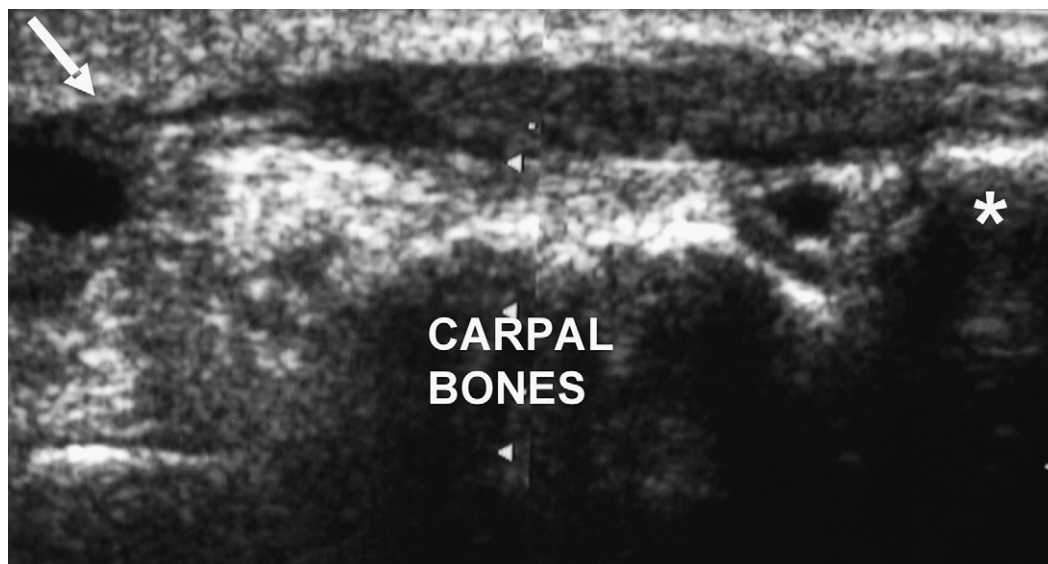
Oblique sagittal ultrasound scan of the wrist, showing thickened distal tendon over the carpus and the first metacarpal (*) and tapering of hypoechoic string until its disappearance (arrow).
